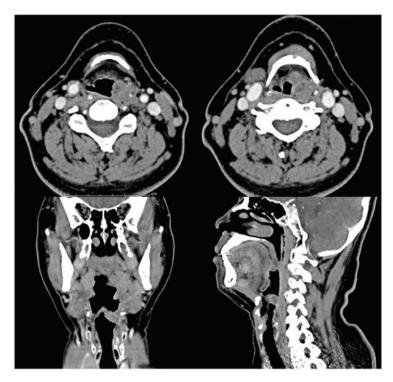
Computed tomography imaging study of the larynx and neck reveals an infiltrative heterogenous enhancing mass involving the left aryepiglottic fold extending to left pyriform sinus. An axial view is shown in the upper images, a coronal and a sagittal view is shown in the lower images.
